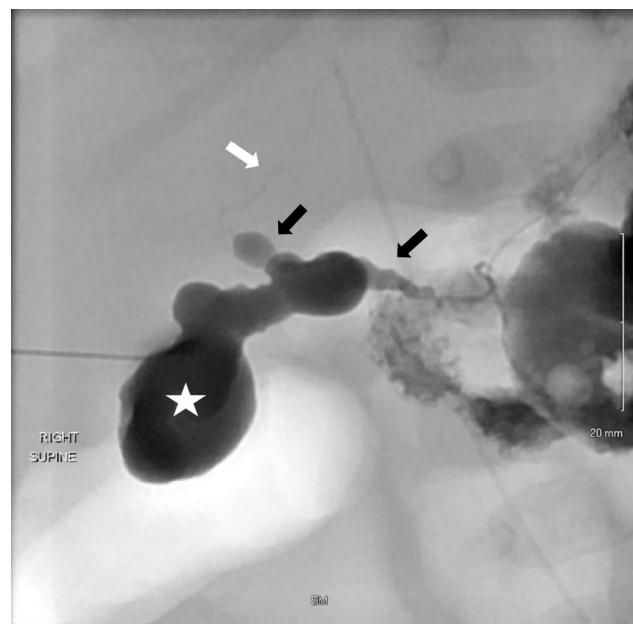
Percutaneous transhepatic cholecystocholangiography in a 2-week-old female with direct hyperbilirubinemia, acholic stools and hepatobiliary scan showing accumulation but no excretion of radiotracer. a Ultrasound image demonstrates a decompressed
